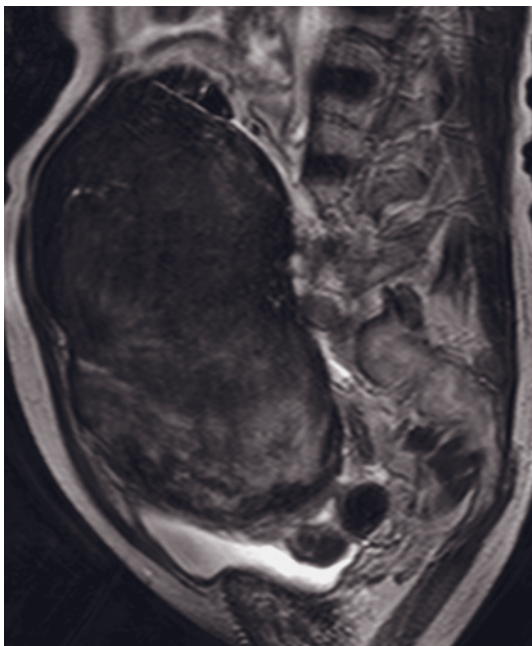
Large ovarian fibroma with necrosis. T1-weighted SE (a), sagittal 512-resolution T2-weighted ETSE (b), and gadolinium-enhanced T1-weighted SE (c) images show an ovarian fibroma. A 12cm mass is present in the pelvis that is homogeneous in signal intensity on the T1-weighted image (arrows, a), heterogeneous on the T2-weighted image (b), and enhances in a mild and heterogeneous
